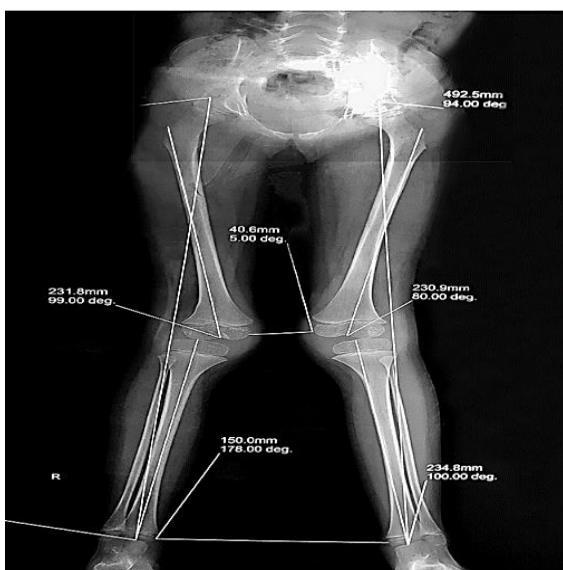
Pre-operative standing radiograph showing genu valgum and lateral subluxation of the tibia. The patellae are not ossified yet, despite the patient being five years old.
